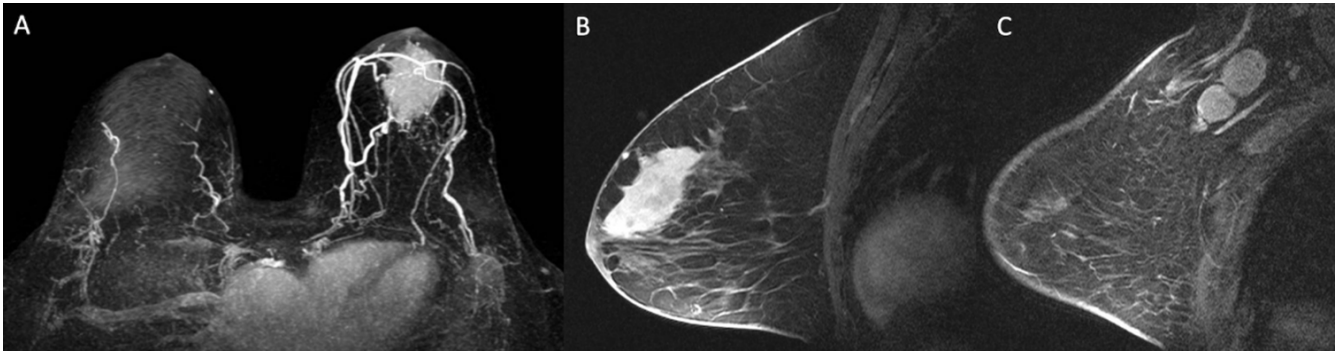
Breast magnetic resonance imaging (A: axial 3D MIP subtraction image; B, C: sagittal T1-weighted enhanced images) showed an irregular mass in the upper quadrants of the left breast (A and B) and left axillary lymph node enlargement (C).
